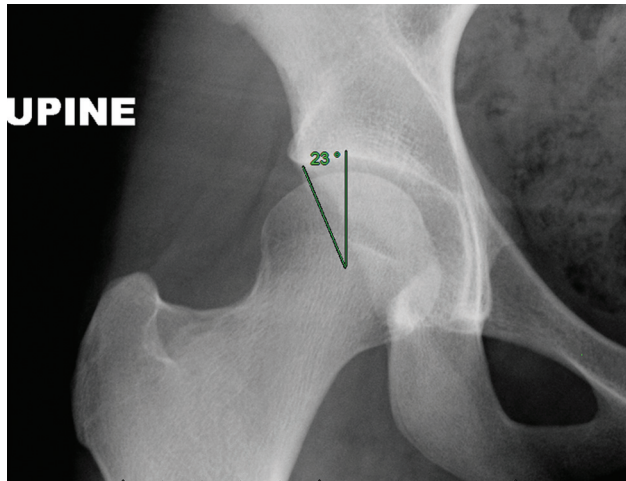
Anteroposterior radiograph of the right hip of a patient with bilateral hip borderline dysplasia. This patient underwent successful bilateral hip arthroscopies, labral repair, and capsular plication. The lateral center-edge angle measures 23°, qualifying this patient as having borderline dysplasia.
